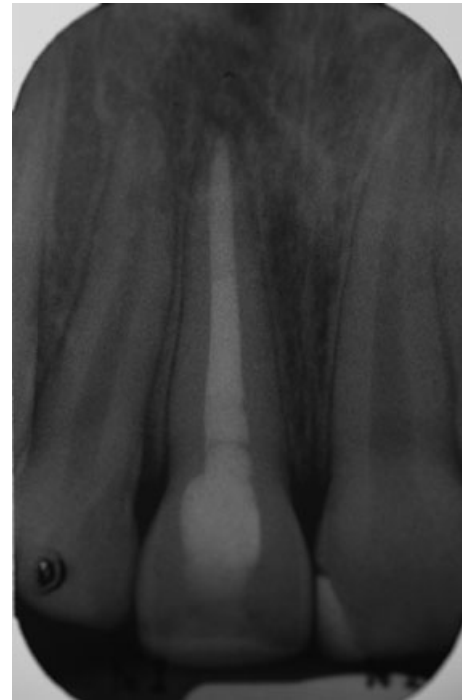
Radiograph showing a complete calcific apical bridge in the upper right central incisor following placement of an mineral trioxide aggregate (MTA) barrier.
